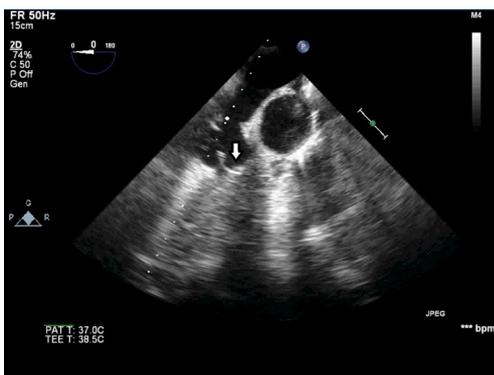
Postoperative echocardiographic study revealing good co-adaptation of the tissue engineered patch (white arrow) and the native aortic valve leaflet.
